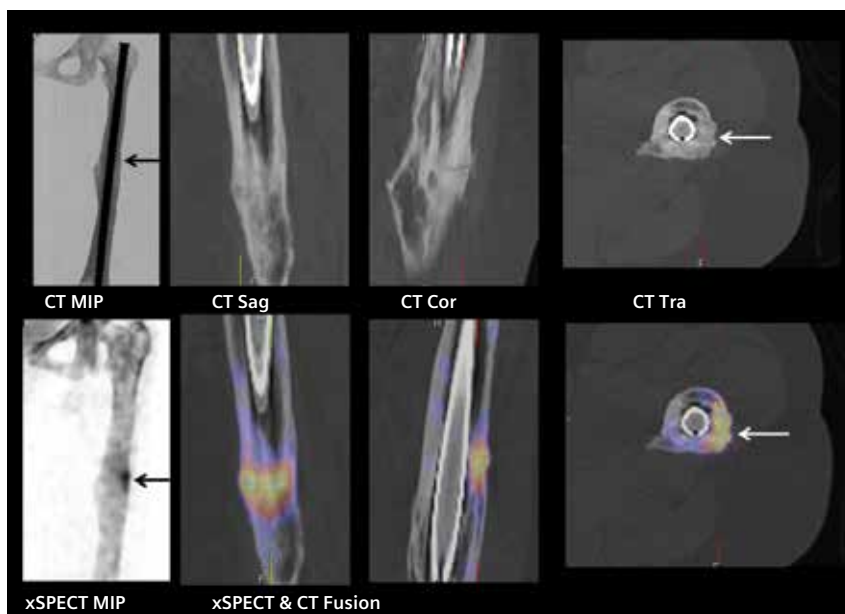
xSPECT Bone maximum intensity projection (MIP) shows a focal area of increased uptake in the lateral cortex of the middle of the shaft of the left femur. CT shows irregular callus formation in the involved femoral cortex (arrows). xSPECT- and CT-fused images show increased uptake of tracer that exactly corresponds to the slightly radiodense callus formation. The pattern of uptake and CT findings suggest a healing sub-acute periprosthetic fissure.
